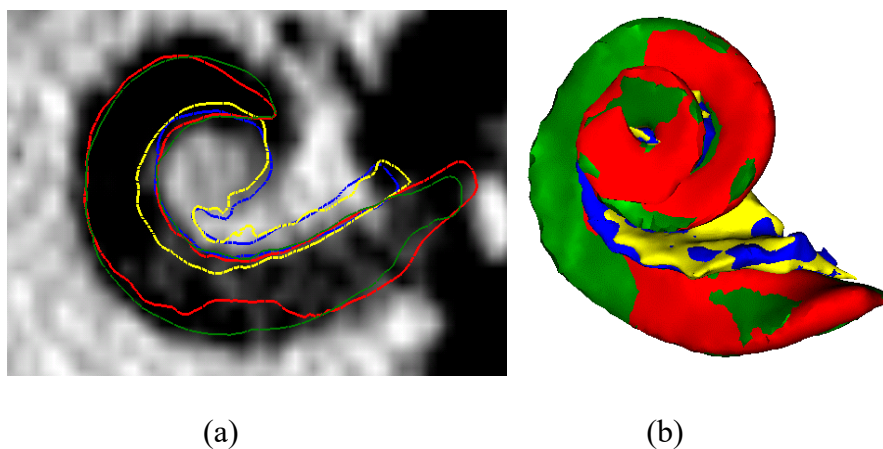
Two rigid shape models containing scala tympani and modiolus. The contours are shown on a CT image (a) and in 3D meshes (b).
